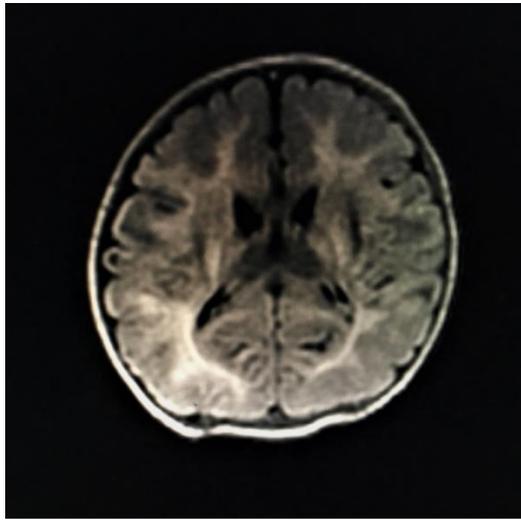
Cerebral and cerebellar atrophy, bilateral hemispheric subcortical and periventricular signal increase, suspicious cystic cavity area at supraventricular level on the first MRI.
